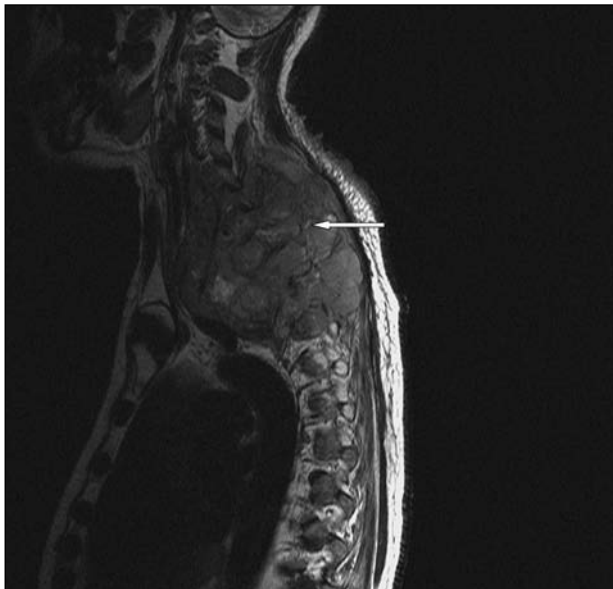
T2 sagittal MR image reveals the large tumour with accompanying multiple vertebral body collapse as well as destruction involving C5- T3 (see arrow).
